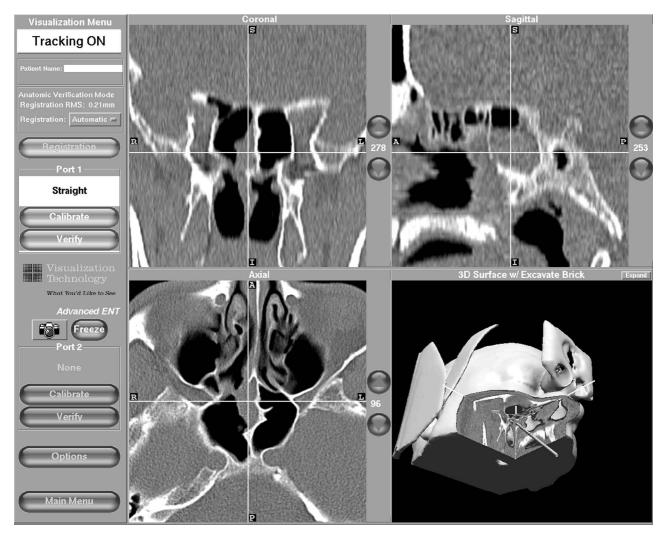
On screen 3-dimensional model and CT images in three planes.
